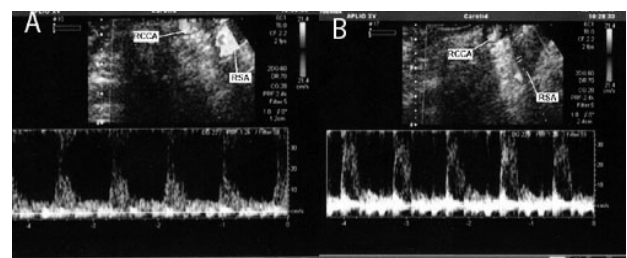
Duplex ultrasound scan. RCCA: right common carotid artery. RSA: right subclavian artery. The flow in the right carotid artery is registered in A. The flow in the subclavian artery is registered in B.
